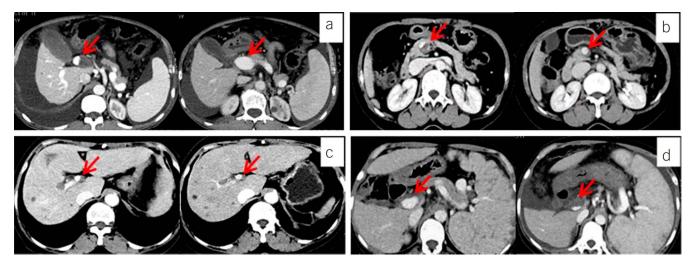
Computed tomography images of portal vein thrombosis outcomes. Thromboses of portal vein with complete recanalization (a), partial recanalization (b), stability (c), or progression (d). The left arrow indicates the position of thrombus and the right indicates the complete recanalization of portal vein in a. The arrows indicate the position of thrombi in b, c and d.
